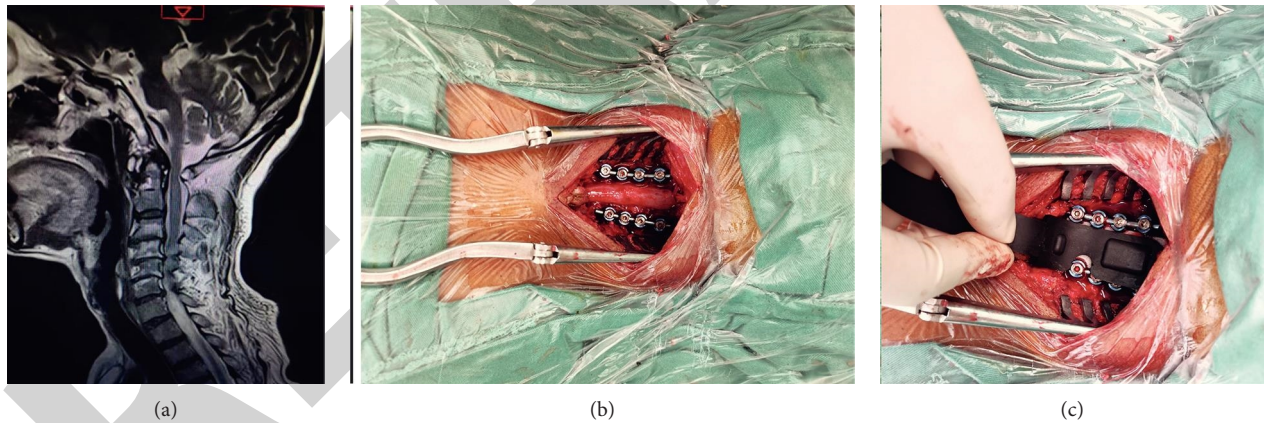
66-year-old male with ASIA grade D underwent laminectomy and spinal blood oxygen saturation measurement. (a) Preoperative MRI. (b) C3–C6 bony decompression. (c) Insertion of the probe for oxygen saturation measurement. Oxygen saturation measurement failed in this patient.
